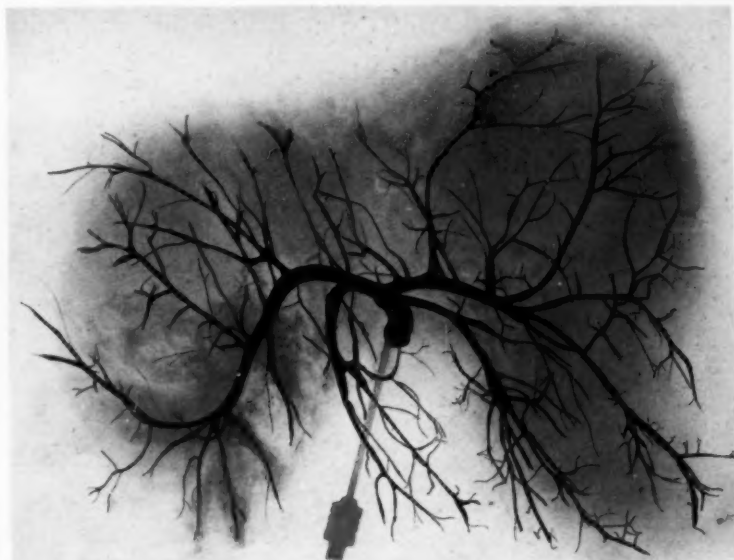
X-ray plate of the injected liver. The intra-hepatic bile ducts as outlined by the lipiodol have been traced over with India ink. Note the absence of any accumulation of the opaque mass, proving that the gall-bladder is not buried in the liver substance.
